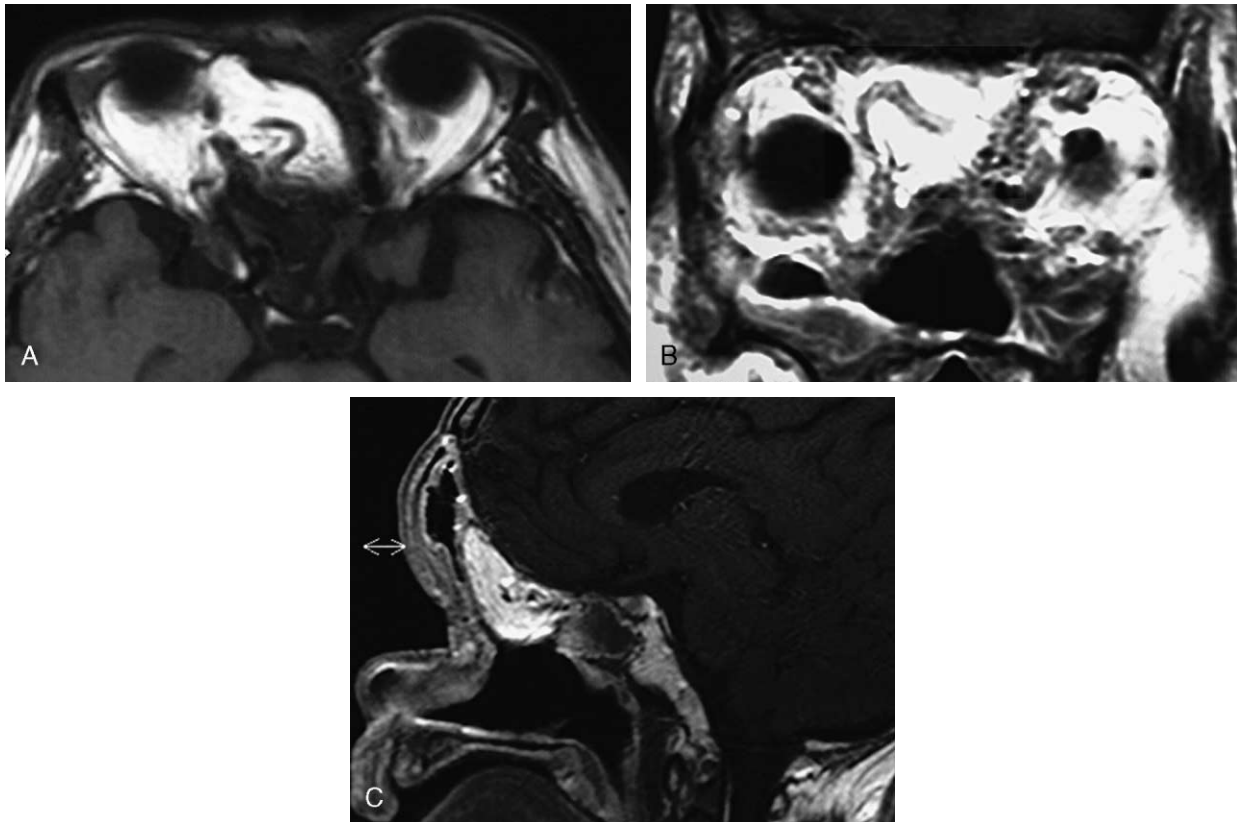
Preoperative magnetic resonance images of patient 3 show extension of lesion involving medial orbital wall and anterior skull base.
